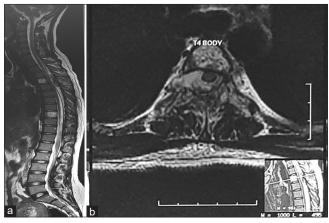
(a) T2-weighted MRI scan(sagittal cut) of the whole spine (b) T2-weighted MRI scan at the level of T4 (axial cut). (a) A well-defined extradural soft tissue mass is seen extending from the inferior end-plate of T3 to the inferior end-plate of T5. Hyperintensities noted at T4 and T9. (b) Lesion seen at the level of T4 with an epidural component surrounding the spinal cord and causing displacement of the cord from the midline.
